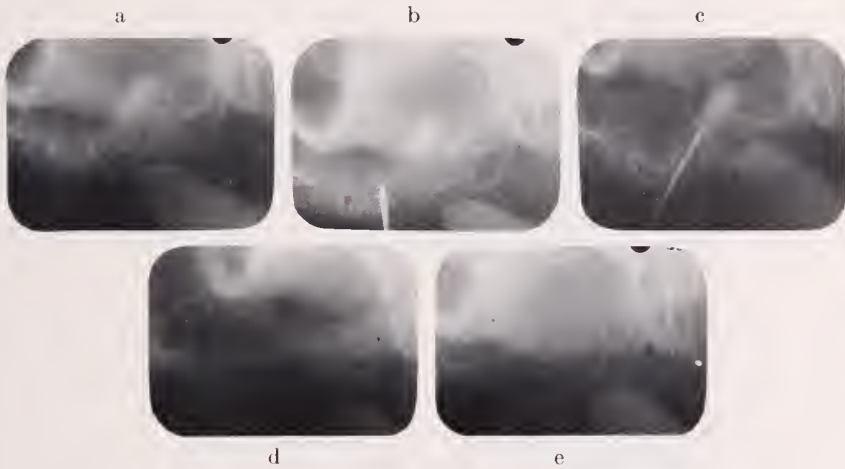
a.* X-ray film depicting root fragment lying at the floor of the antrum.
